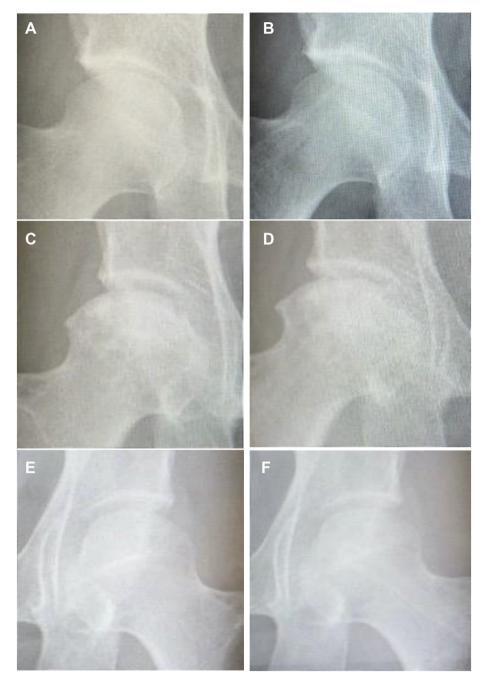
Result of disease staging using X-ray. No stage progression is observed. A: Preoperative image of patient 1. B: Postoperative image of patient 1. C: Preoperative image of patient 2 (right hip). D: Postoperative image of patient 2 (right hip). E: Preoperative image of patient 2 (left hip). F: Postoperative image of patient 2 (left hip).
